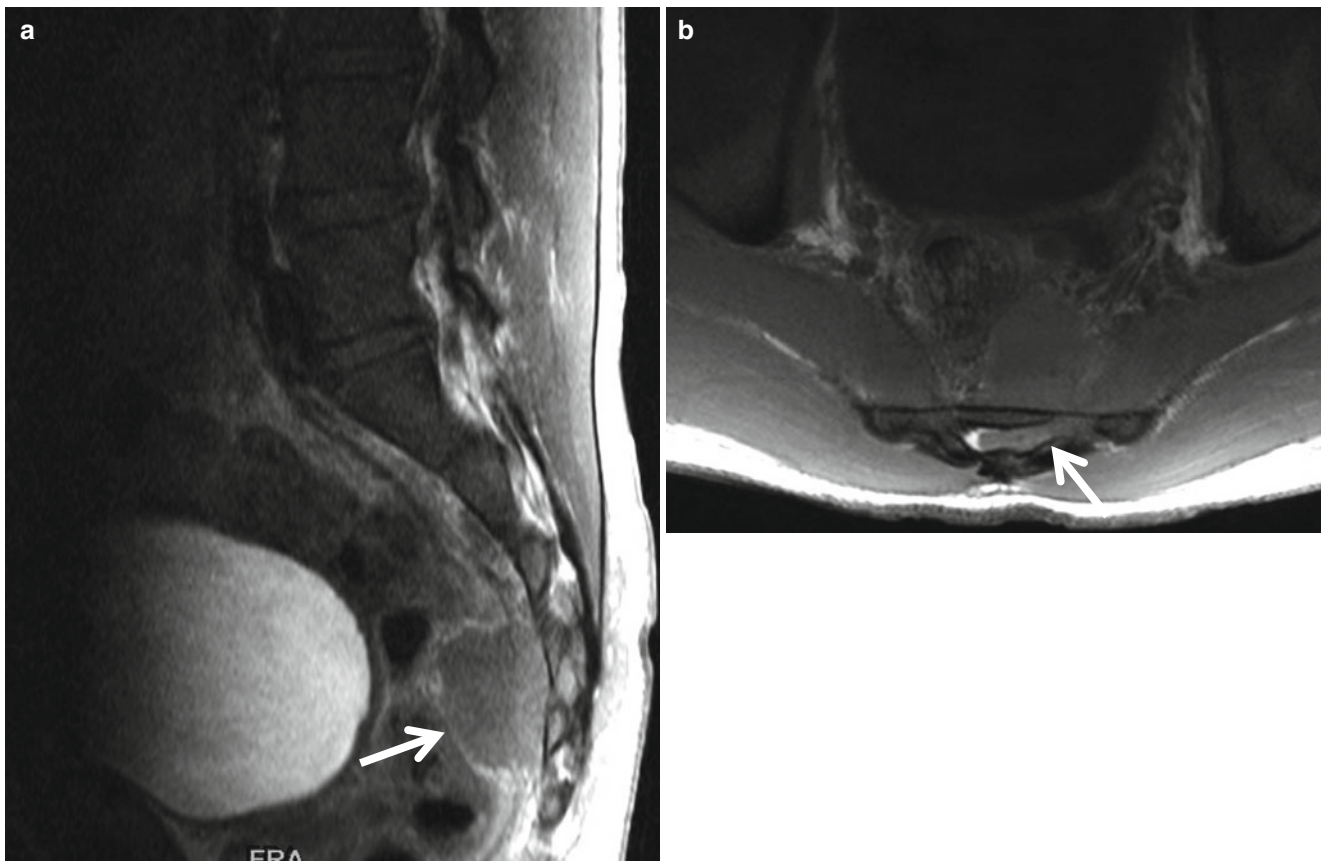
Granulocytic sarcoma in a patient with acute myelocytic leukemia. (a) T2-weighted sagittal image shows well-defined presacral mass (*arrow*) exhibiting isointensity. (b) Presacral mass is enhanced
